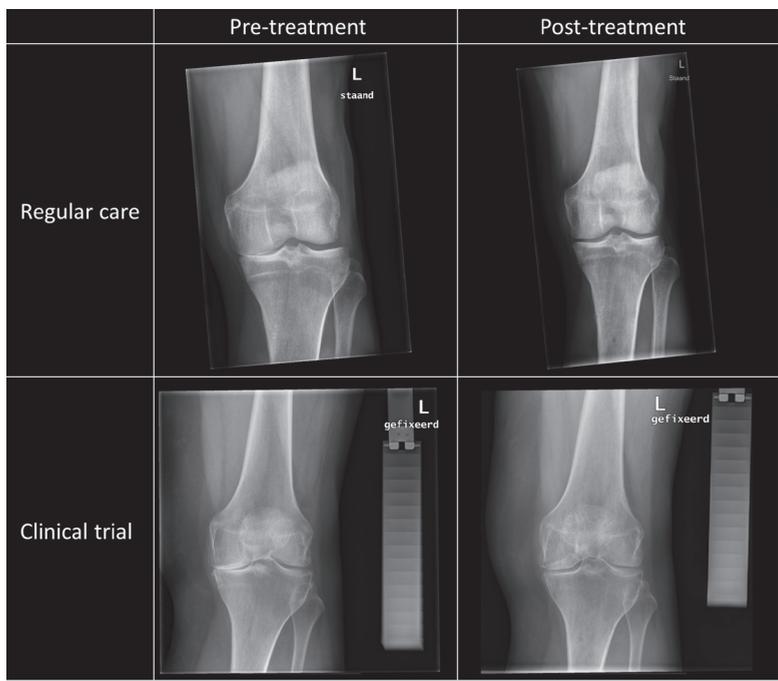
Representative radiographs pre-treatment and 1 year post-treatment for regular care and clinical trial patient. Note the aluminum step wedge needed for joint space width quantification as used in clinical trials.
